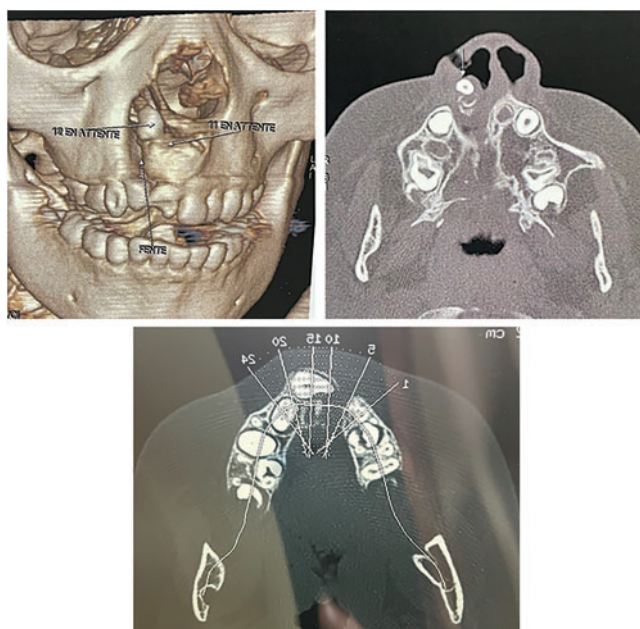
An ectopic tooth is visible in the right nasal cavity on CT scans.
